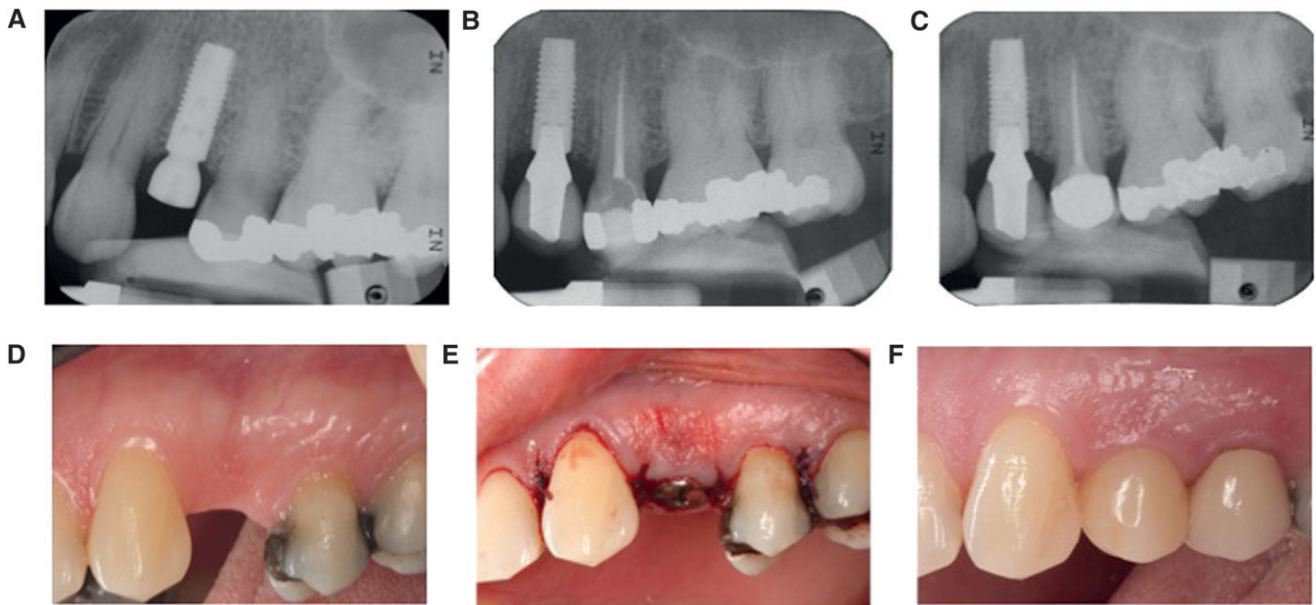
Traditional flap placement. A through C) Standardized radiographs taken at baseline implant placement (A), 3-month crown placement (B), and 15-month follow-up (C). D through F) Photographs of initial (D), postoperative (E), and 15-month follow-up (F) clinical situation.
